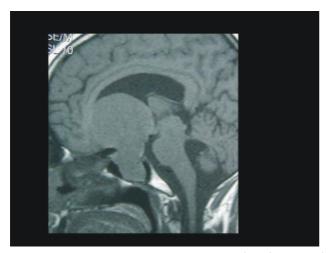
Post-contrast T1-weighted coronal MR image showing Grade I giant pituitary tumor. B. Post-contrast post-operative T1-weighted coronal MR image showing complete excision of the tumor.
